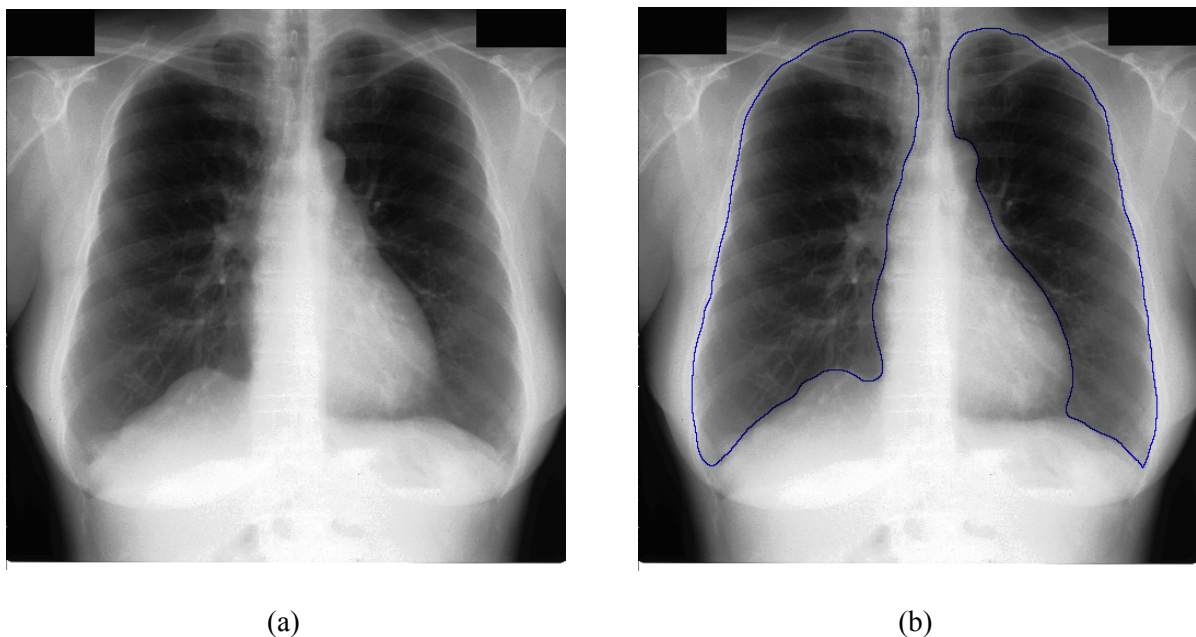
Chest radiograph (case JPCLN113) with the visible lung region outlined (b).
